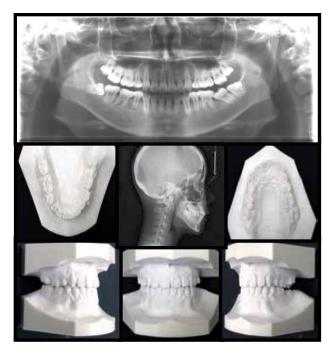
Post- treatment radiograph and model photographs.
